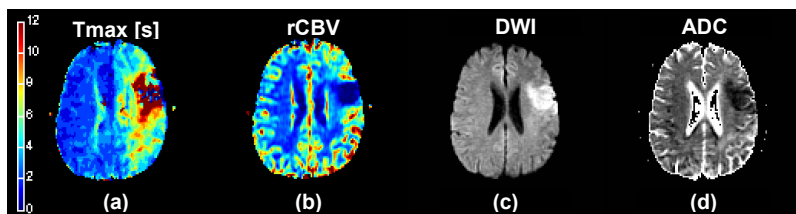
Example of case from DEFUSE database. Maps: (a) Tmax, (b) relative CBV, (c) isotropic DWI for $b=1000$, and (d) apparent diffusion coefficient (ADC).
